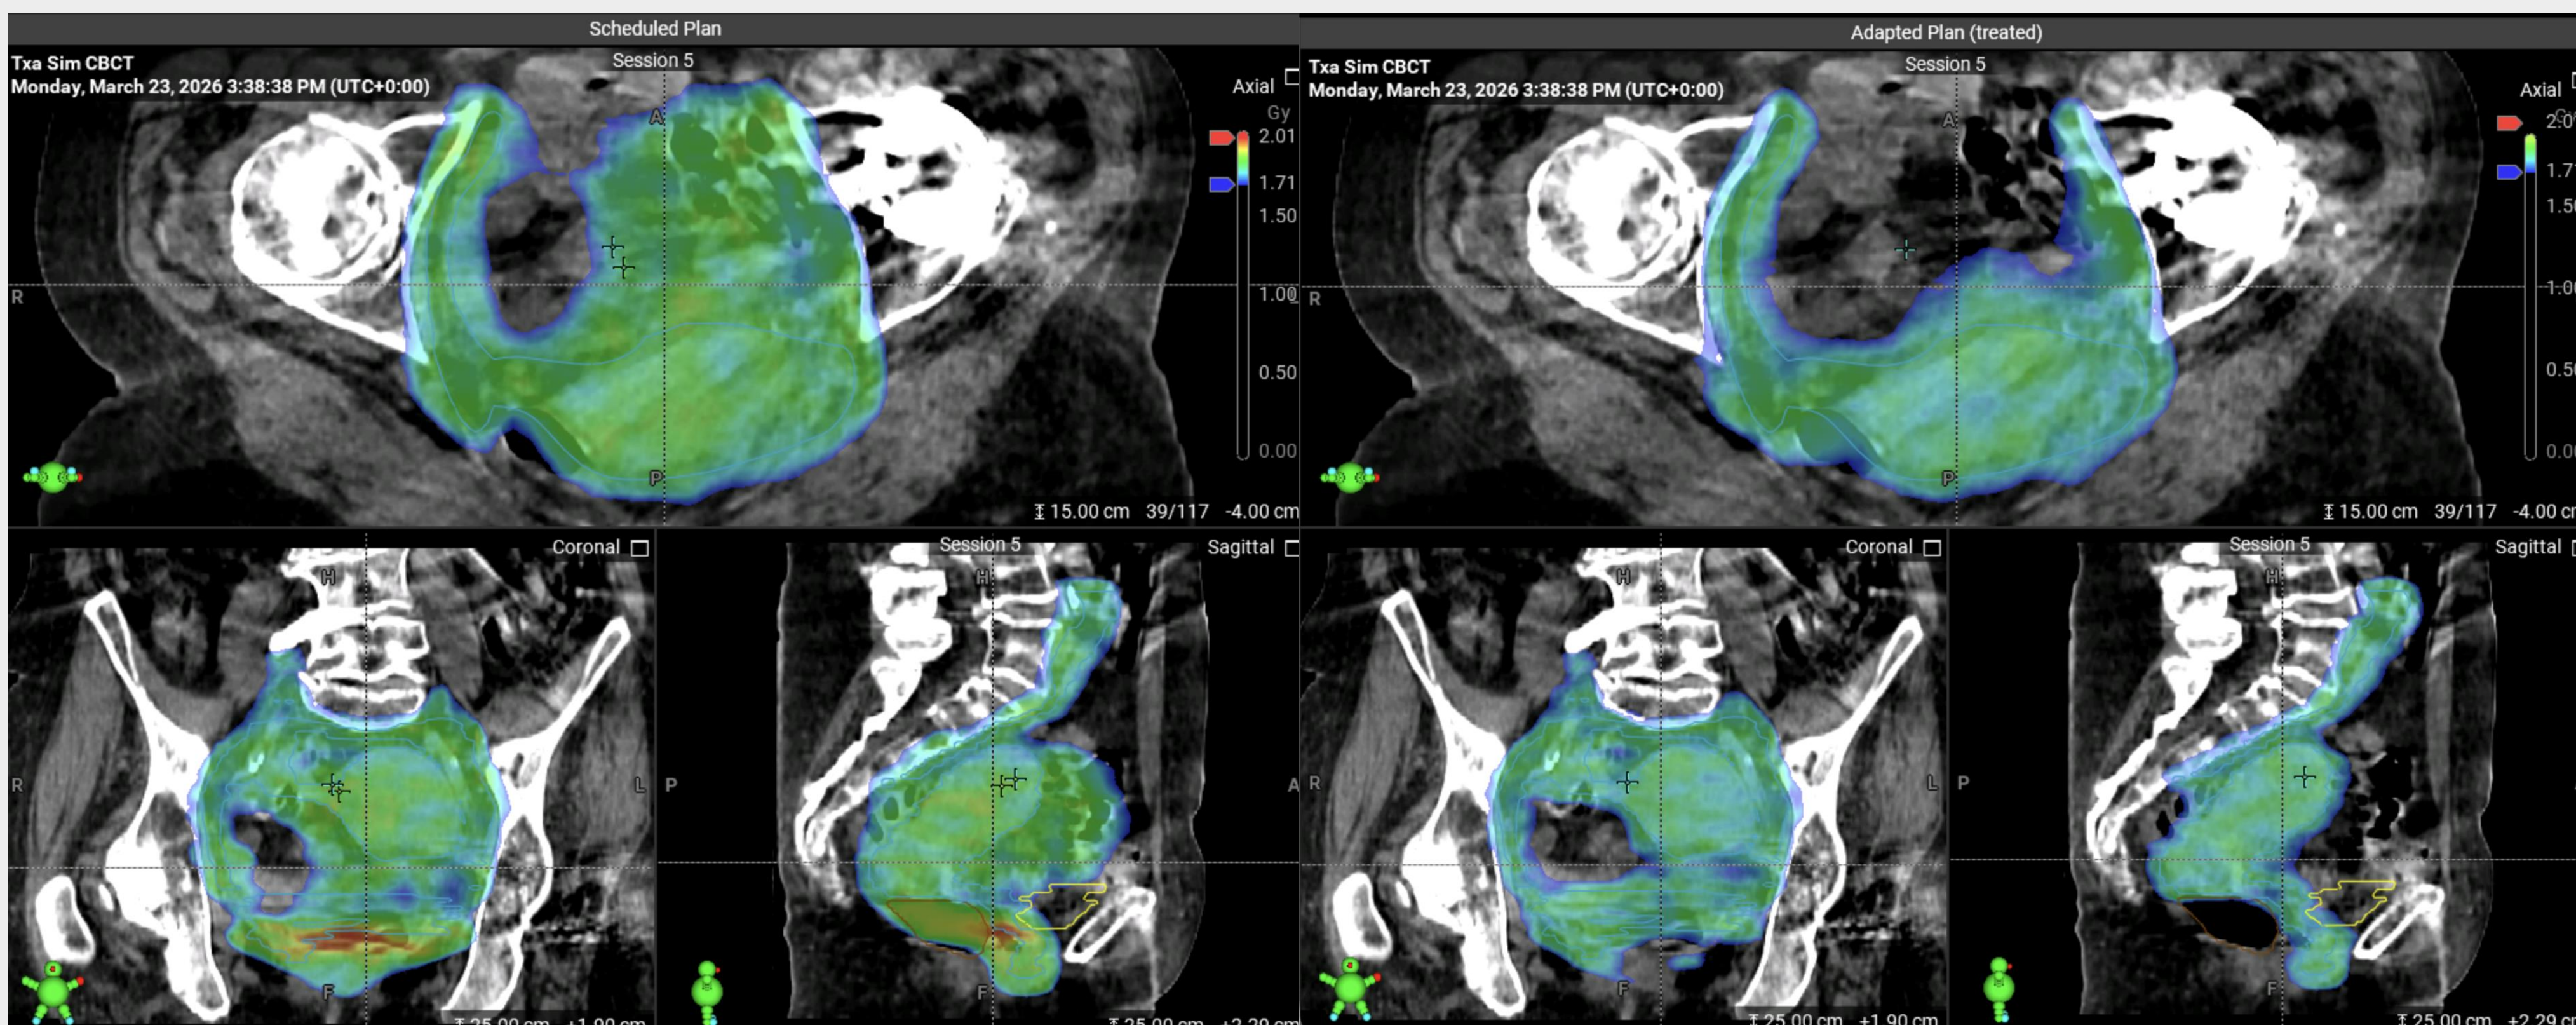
Comparison of scheduled (left) and adapted (right) dose distributions on HyperSight CBCT for Fraction 20. The adapted plan reduced high-dose regions while maintaining target coverage. Dose wash: 1.71-2.01Gy (95-112% of prescribed 1.8 Gy per fraction)
